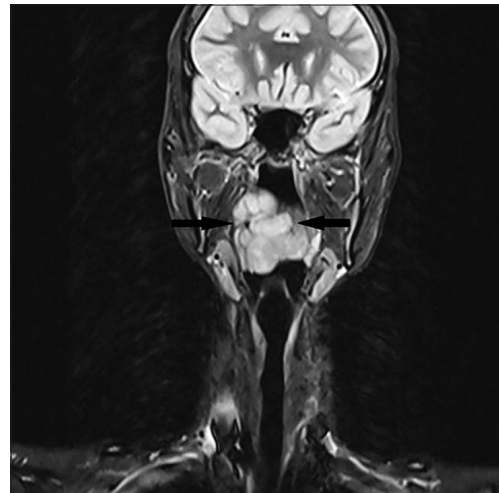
Magnetic resonance imaging coronal section showing soft tissue mass (marked by arrow) arising from soft palate reaching up to the posterior pharyngeal wall causing obliteration of nasopharyngeal and oropharyngeal airway
